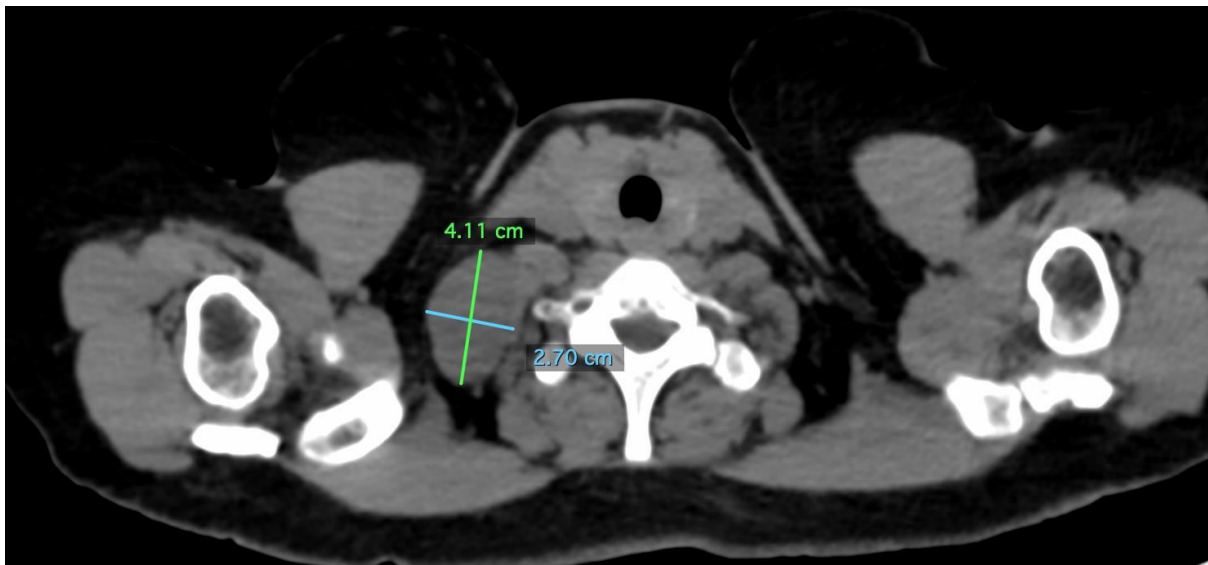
CT ANGIOGRAPHY - Plain CT axial image shows a well defined smoothly margined heterogenous density lesion in right supraclavicular region lateral to right middle scalene muscle.
